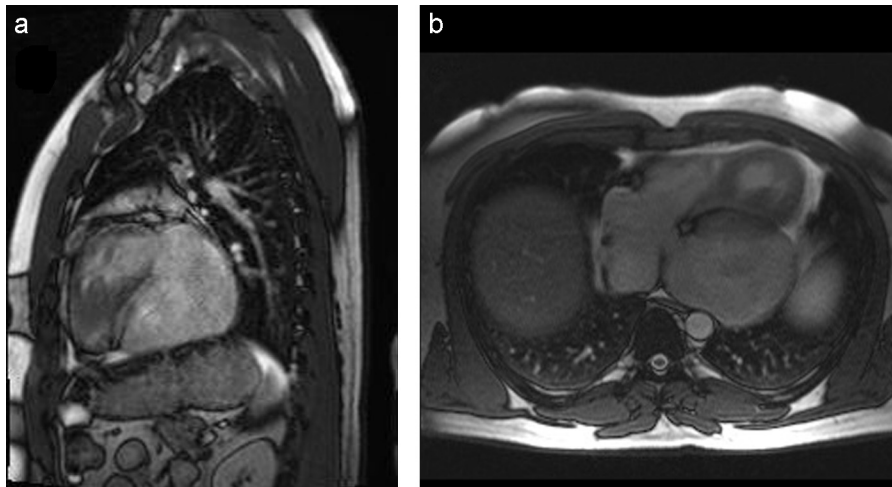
Magnetic resonance imaging of the thorax confirming a large aneurysm arising from the left atrium in sagittal plane (a) and axial plane (b).
